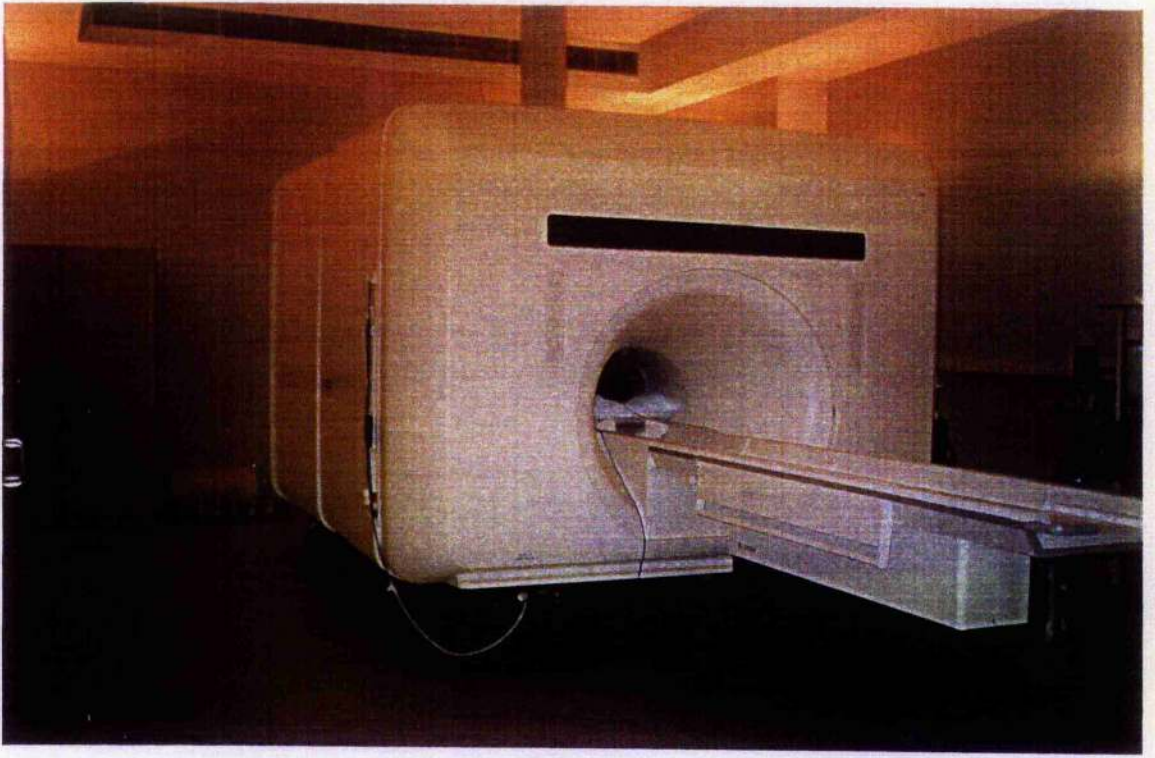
Magnetic Resonance Imaging (MRI) for scanning body tissues
